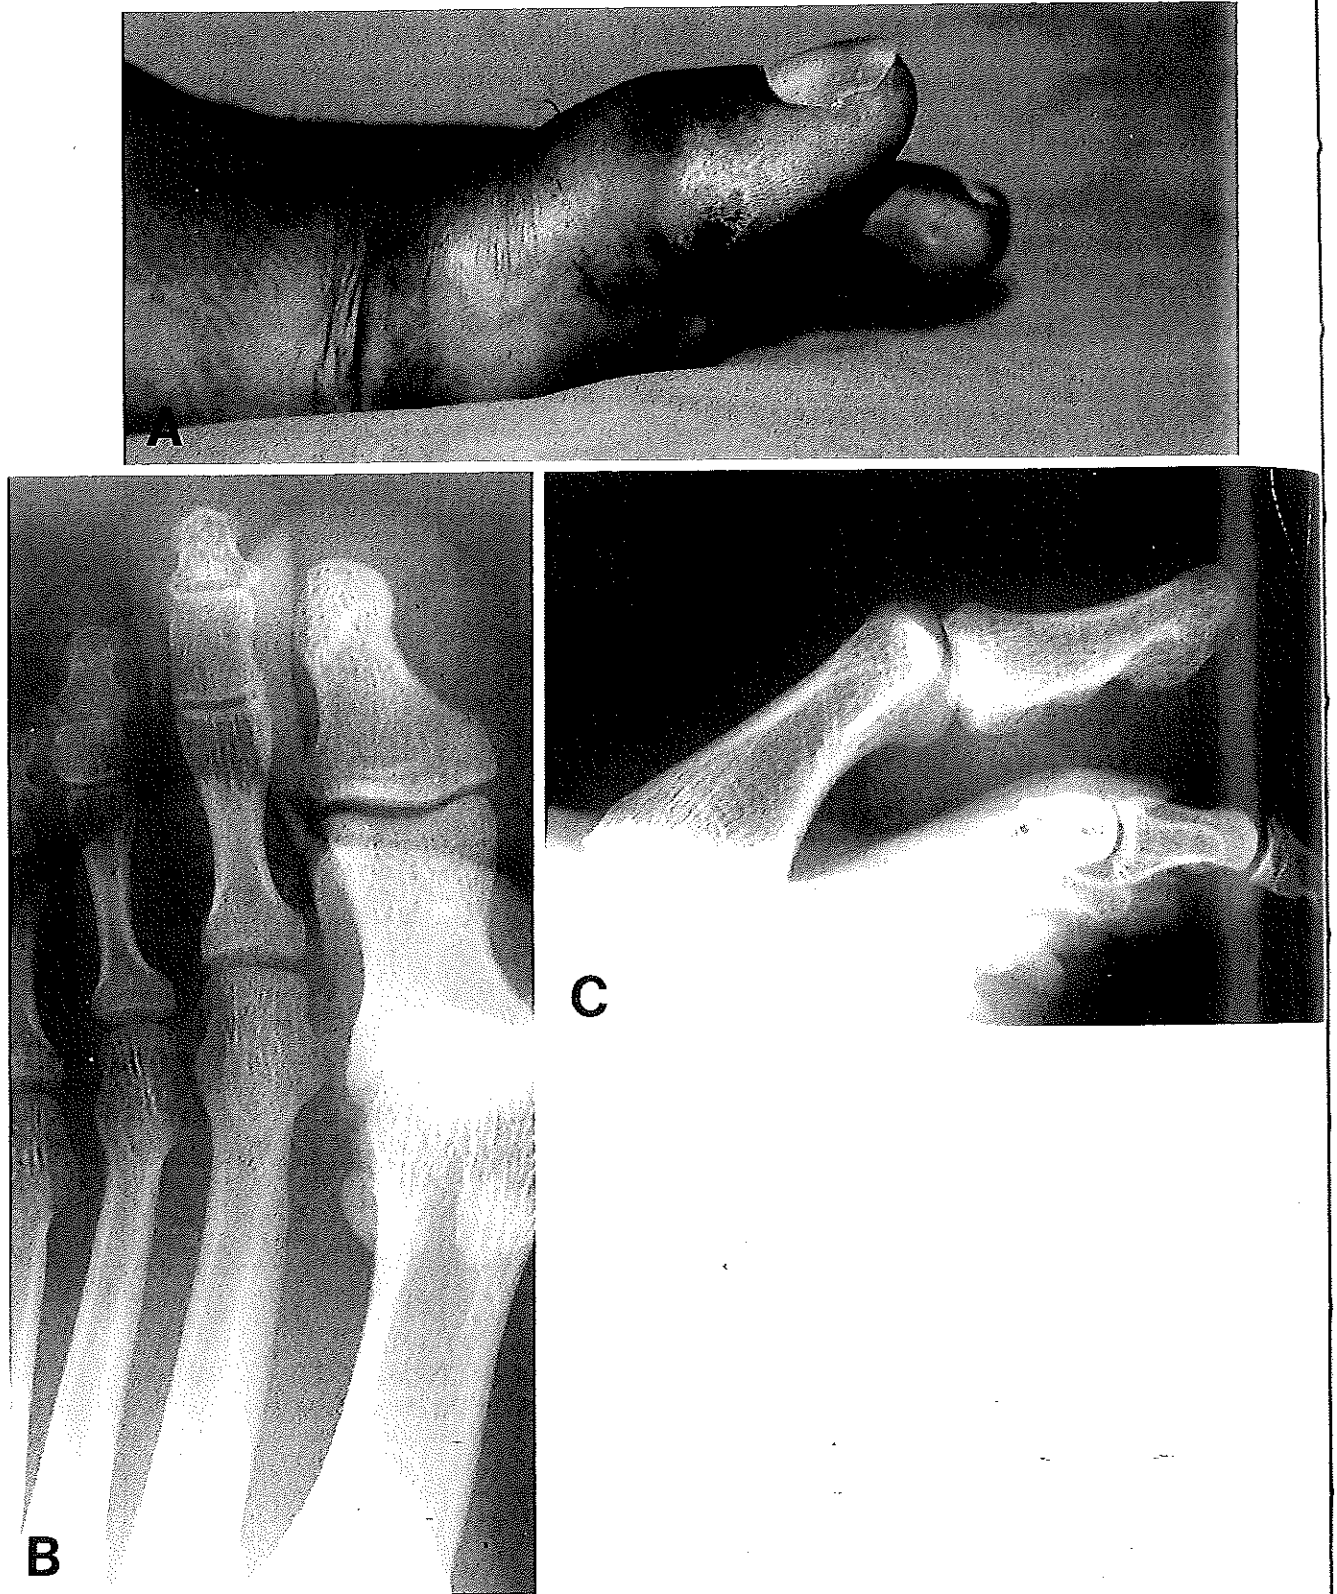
Jahss type I dislocation of first MP joint. A, Clinical photograph. B, AP radiograph. C, Lateral radiograph.
